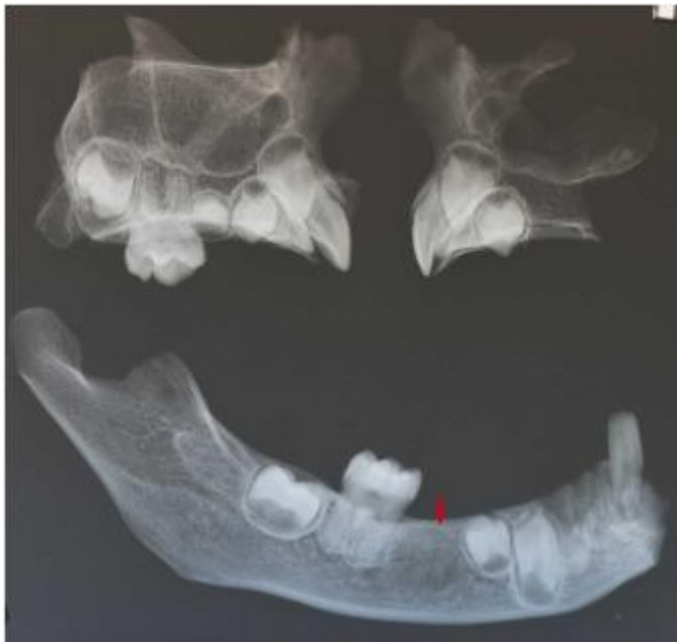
Panoramic radiograph of the maxilla and mandible of individual FA090 [1296]. The red arrow indicates the radiotransparent area substituting for the germ of the mandibular right second permanent premolar.
